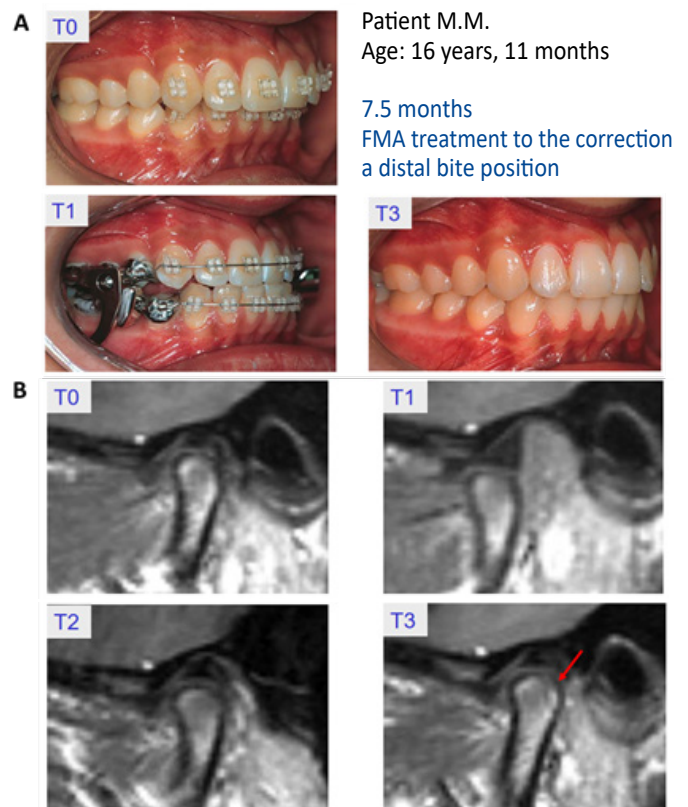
A) Intraoral position of an Angle Class II malocclusion before treatment (T0), during the fixed functional phase (T1) and after treatment (T3); B) MRI images before treatment (T0), during the fixed functional phase (T1), after 3 months of treatment (T2) and after treatment (T3) (image from 5th SGS)
